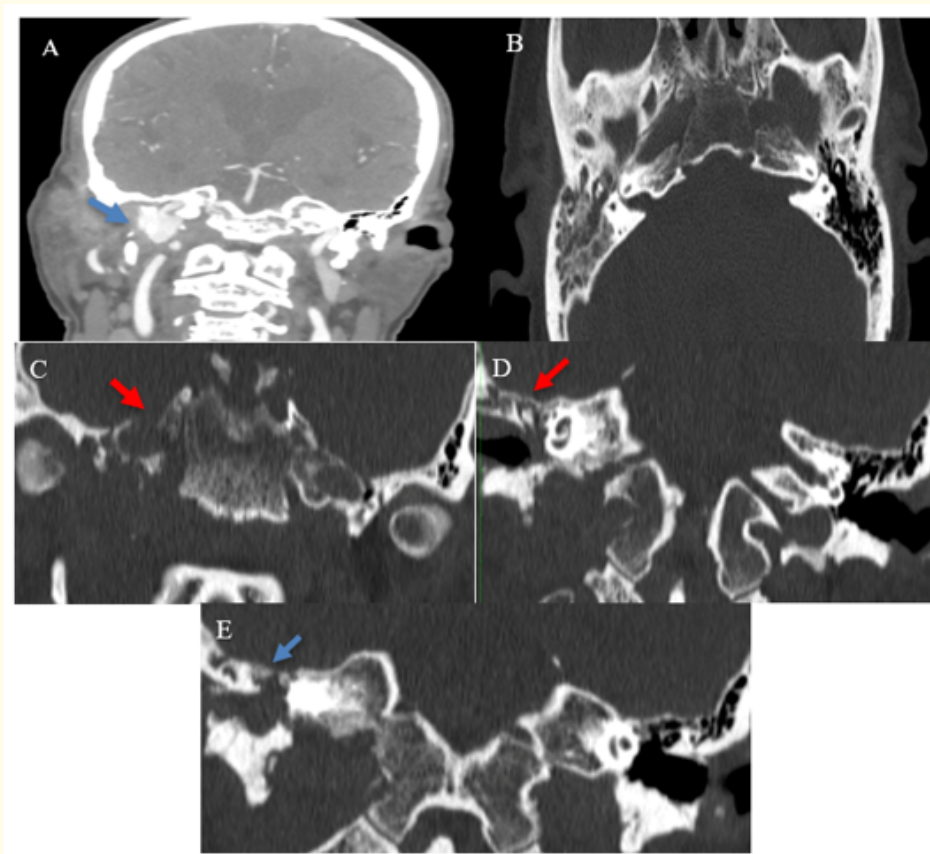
CT images of the temporal bone and carotid artery.
